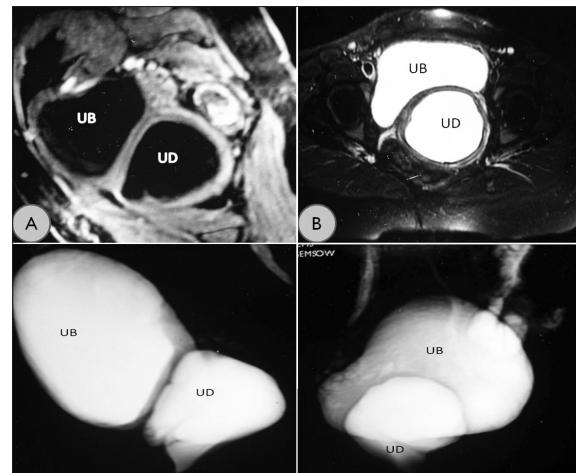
(a) T1-weighted MRI image showing the urethral diverticulum (UD) and urinary bladder (UB) in the sagittal plane. (b) T2-weighted cross-sectional image showing the diverticulum. (c, d) Reconstructed T2-weighted MRI images showing relationship of urethral diverticulum with urinary bladder
